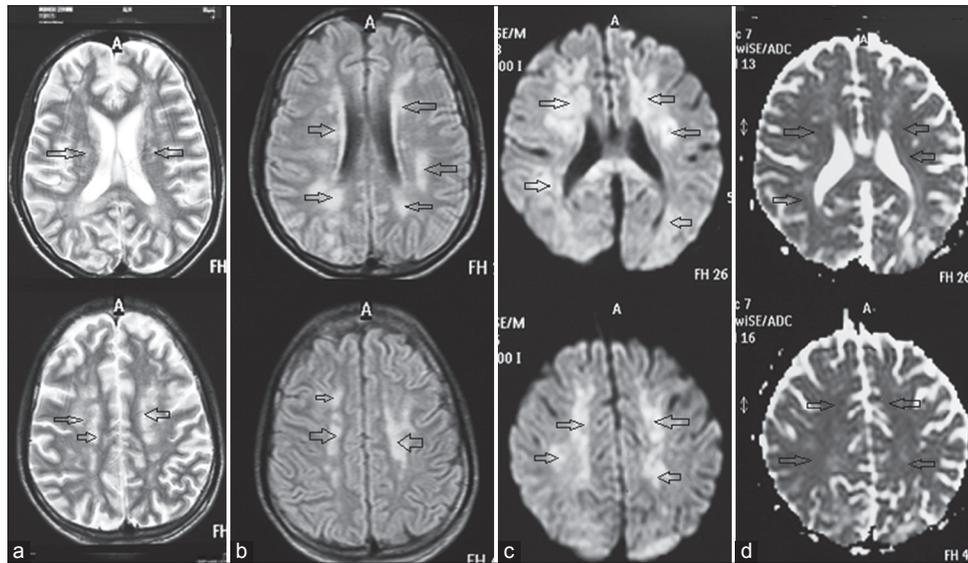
Magnetic resonance imaging at 3 weeks. (a) T2-weighted images showing small focal and confluent areas of hyperintensities seen in the deep and periventricular white matter of bilateral cerebral and cerebellar hemispheres, in bilateral corona radiata and basal ganglia. As compared to initial magnetic resonance imaging, the changes are more prominent in this scan with greater signal alteration. (b) Fluid-attenuated inversion recovery sequence showing hyperintensities in above region. (c) Diffusion-weighted imaging images showing restricted diffusion in the above areas and the appearance of "starfield pattern." (d) Apparent diffusion coefficient map showing mild reversal in the above region
